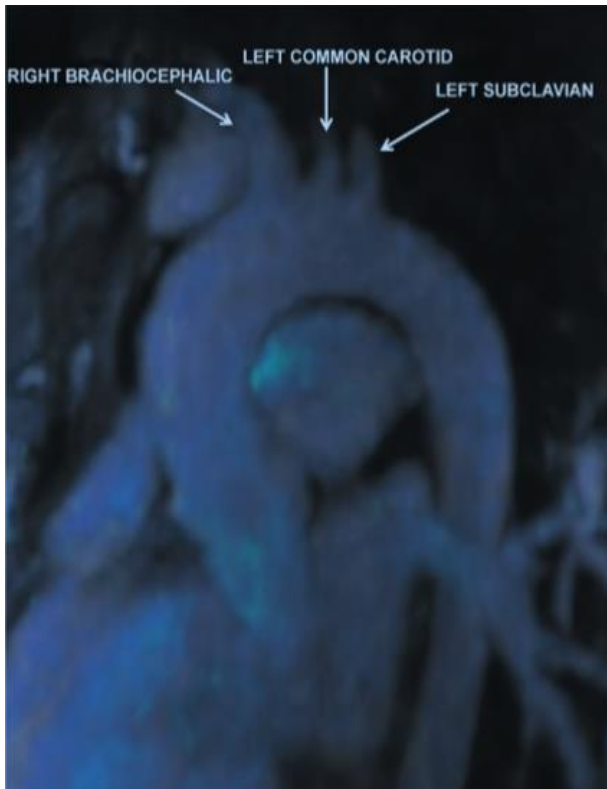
MRI (Magnetic Resonance Imaging) of the Aortic Arch Branches.
